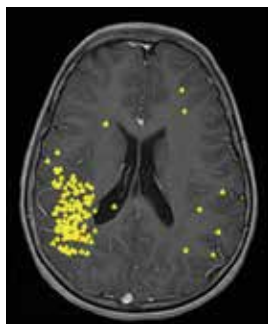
Total 127 MEG dipoles in Case 3. A total of 127 MEG dipoles are shown on one transparent axial MRI, consisting of 120 over the right hemisphere and 7 in the left hemisphere. Over the right hemisphere, 102 MEG dipoles are clustered in the right temporal and parietal regions. Dipole moments were not shown in this figure.
